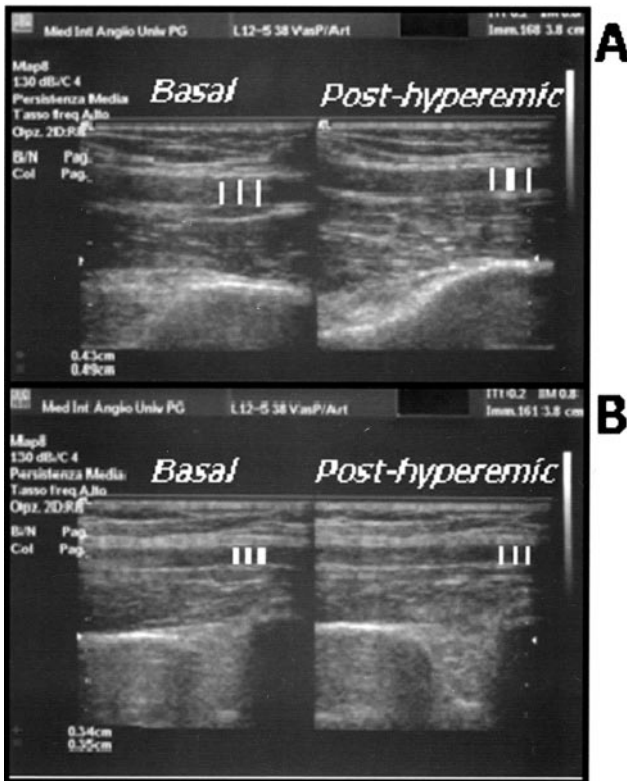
Brachial flow-mediated vasodilatation (FMV) assessed on the brachial artery by ultrasonography in a normal control subject (A) and in a patient with RA (B). FMV, expressed as the relative increase in brachial artery diameter during hyperemia and defined as $100 \times (\text{posthyperemia diameter} - \text{basal diameter}) / \text{basal diameter}$, was 12% in the normal subject and 3% in the RA patient.
